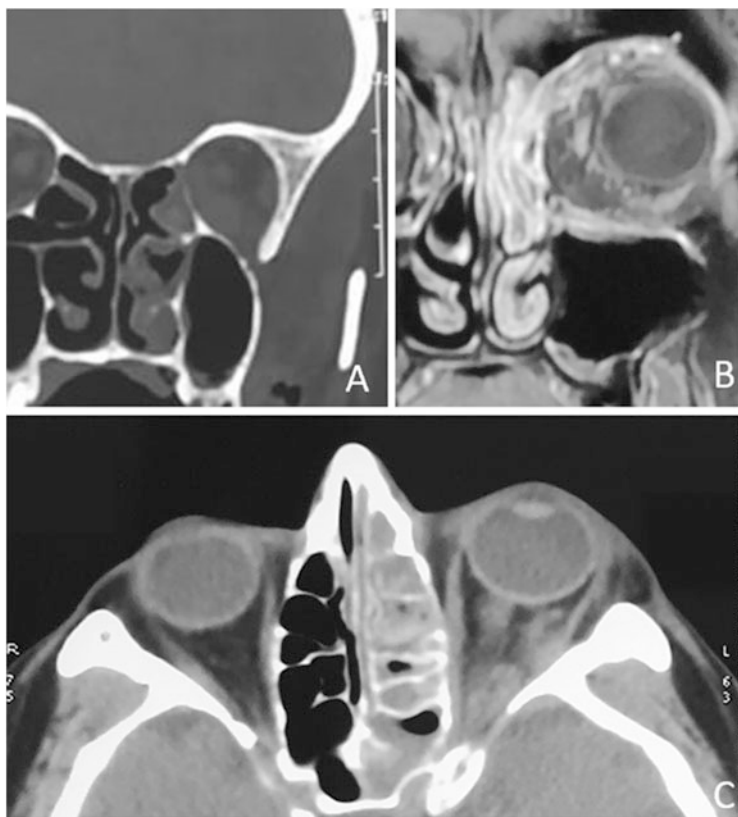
Radiological features of rhino-orbital mucormycosis: (A) shows the CT scan of a patient showing a patchy hyperdensity involving the left ethmoid sinus and nasal cavity (turbinates), with adjacent edema of the left medial and inferior recti. (B) shows the CEMRI orbit and paranasal sinuses of another patient. This T1 weighted image shows patchy enhancement of the ethmoid sinus and adjacent infero-medial orbital involvement. The enlargement of inflamed nasal turbinates is also noted. (C) shows a heterogenous opacity involving the entire left ethmoid sinus. There is predominant left orbital apex involvement seen as a heterogenous hyperdensity at the apex, involving the medial rectus, the optic nerve sheath and surrounding fat
